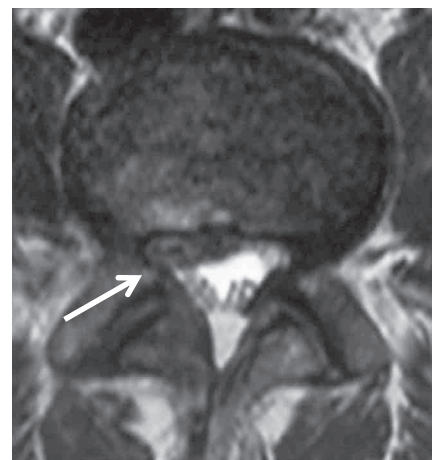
STIR-MRI for a case showing exiting nerve irritation. It indicates left L5 nerve root swelling and edema.
